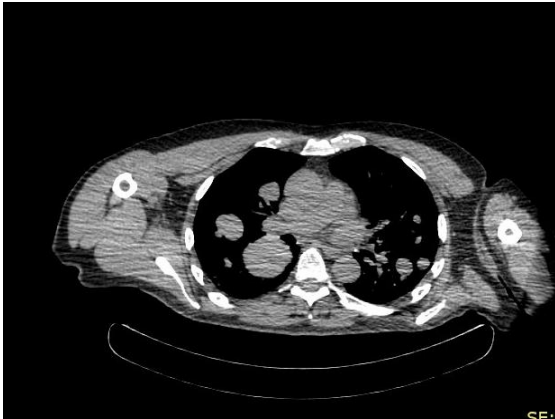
Chest CT demonstrating innumerable bilateral lung metastases, largest in the inferior aspect of the right upper lobe measuring 66 x 73 mm
